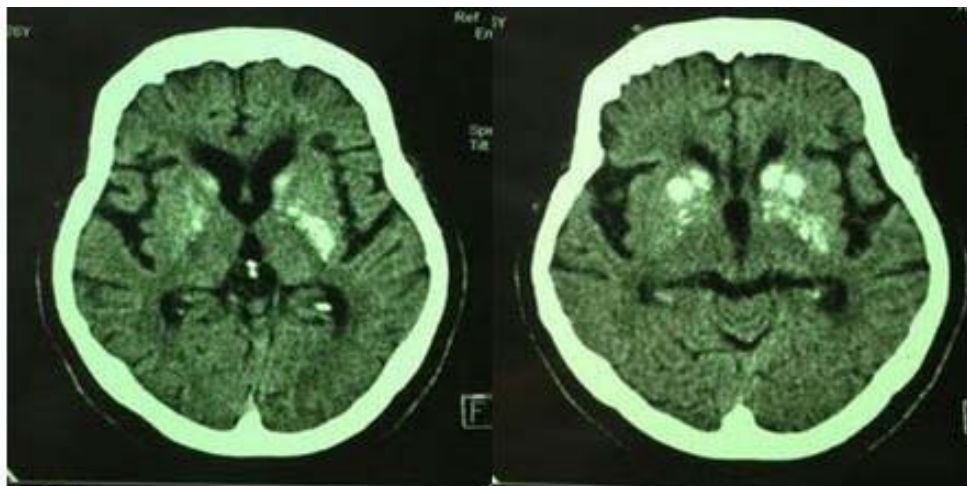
Non-contrast CT of the brain showing images of bilateral calcifications involving structures of the basal ganglia, thalamus, centrum semiovale, and dentate cerebellar nuclei.
